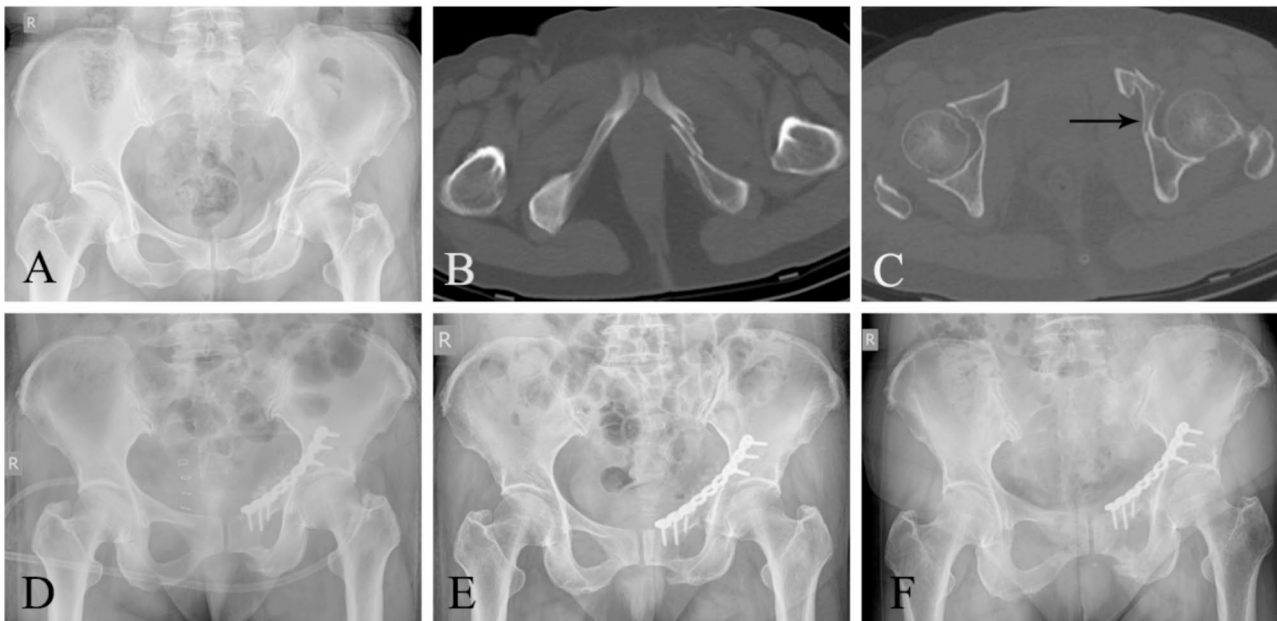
An elderly female patient with left superior and inferior ramus of the pubis, and acetabular anterior column fractures caused by a motor collision was treated through the modified Stoppa approach. A: Presurgical AP radiograph. B, C: axial view. D: Postoperative AP radiograph after four days. E: X-ray radiograph after one month. F: X-ray radiograph showed the fracture union after three months
